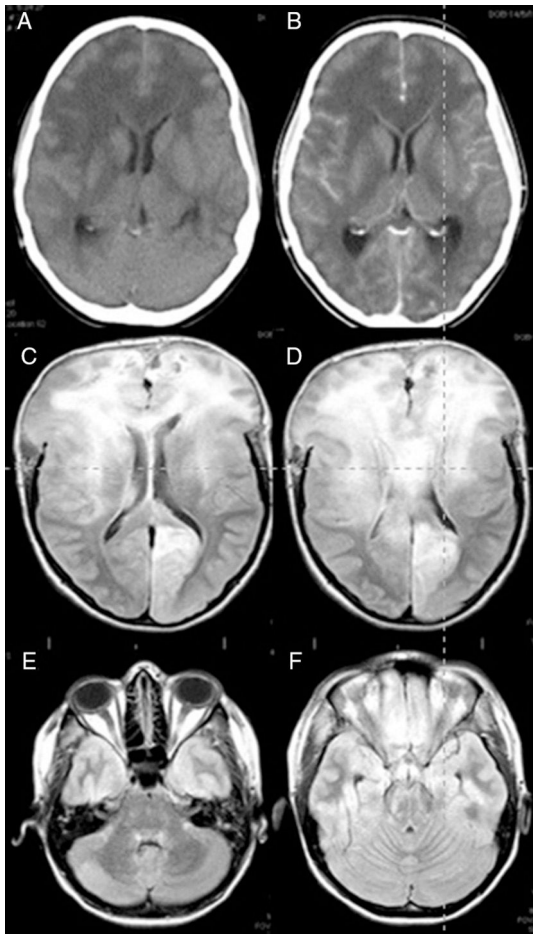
Brain CT (A and B) and FLAIR MRI (C–F) images. (A) Predominant presence of diffuse white matter hypodensity in both frontal lobes and involvement of the corpus callosum indicating vasogenic oedema. Convexity sulci effacement is seen. (B) Image was taken after the administration of contrast, showing no focal enhancement. (C) Signs of intracranial hypertension involving both frontal lobes and the corpus callosum are present. (D) Brain herniation persists despite extensive bilateral frontal craniectomy. (E and F) Infratentorial diffuse involvement is also present.
